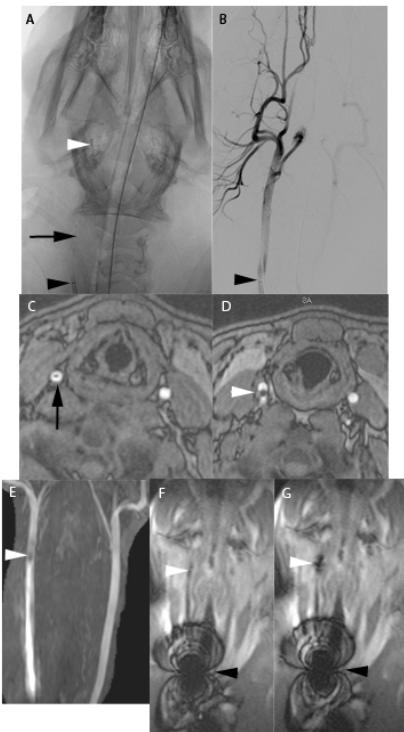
(Left). Unsubtracted X-ray image (A) demonstrates deflection catheter tip coils (white arrowhead), microcatheter shaft with lead wires (black arrow), and guiding catheter (black arrowhead) in the right CCA. Only the guiding catheter tip marker is readily evident on the equivalent DSA image (B). Susceptibility from the catheter shaft lead wires (black arrow) and catheter tip (white arrowheads) is seen on axial MRA (C, D), coronal MRA MIP (E), and coronal SSFP (F). With 300 mA current applied (G), the catheter tip coils are more apparent (white arrowhead). Guiding catheter tip artifact due to metallic marker band is very prominent on the SSFP sequence (F, G).
